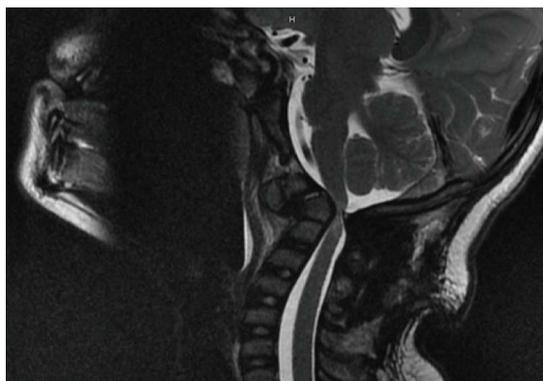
Magnetic resonance imaging showing severe cord compression at the craniocervical junction in a 6 year-old child with instability and myelopathy due to previous failed fusion for atlanto-axial instability.
